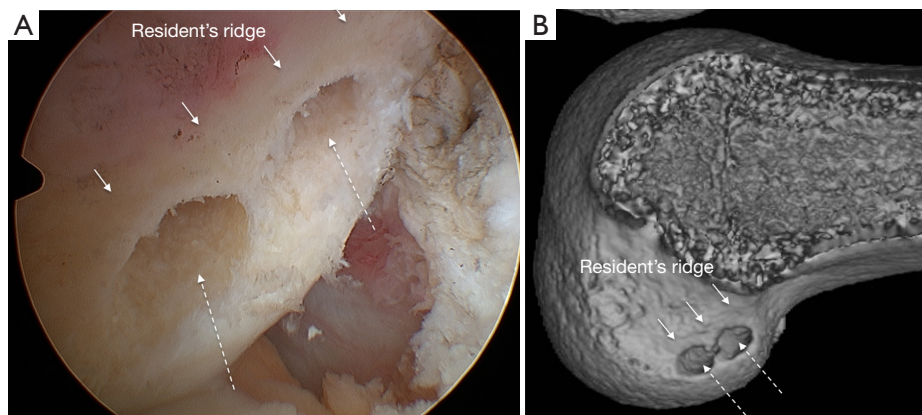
Two femoral tunnels created inside the attachment areas for hamstring tendon graft (dotted arrows). (A) Arthroscopic view through the anteromedial portal; (B) apertures on 3D CT image.
